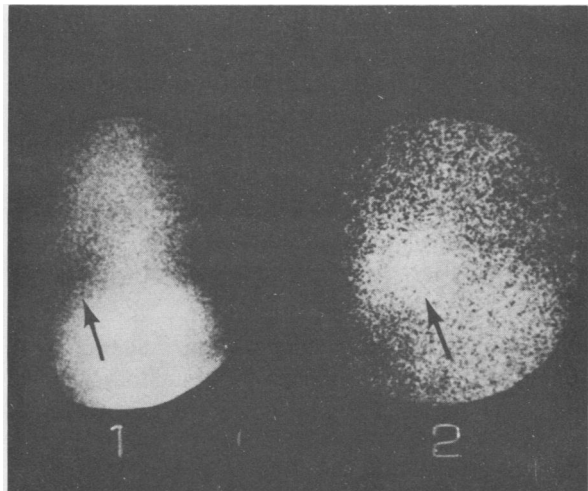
(Case 4) Left, right lateral liver-lung scintigraph (1) using ^{99m}Tc -sulfur colloid and ^{99m}Tc -human albumin microspheres shows posterior separation of the hepatic and pulmonary images. Right, a ^{67}Ga scintigraph (2) obtained in the same position shows ^{67}Ga localization in the area of separation.
